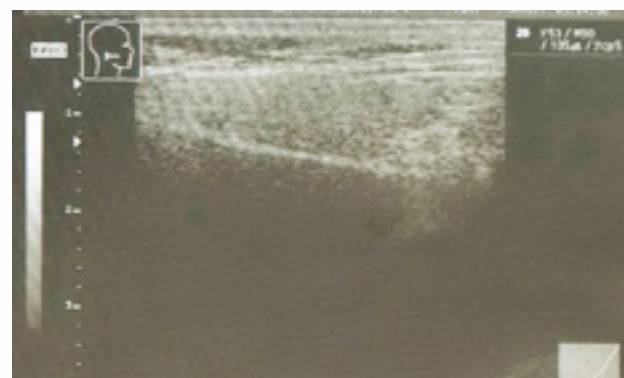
Ten-year-old child K. Ultrasound image of the parotid gland without lesions. The capsule is detected in the form of the echo-dense line, and gland parenchyma has homogeneous fine-grained structure
